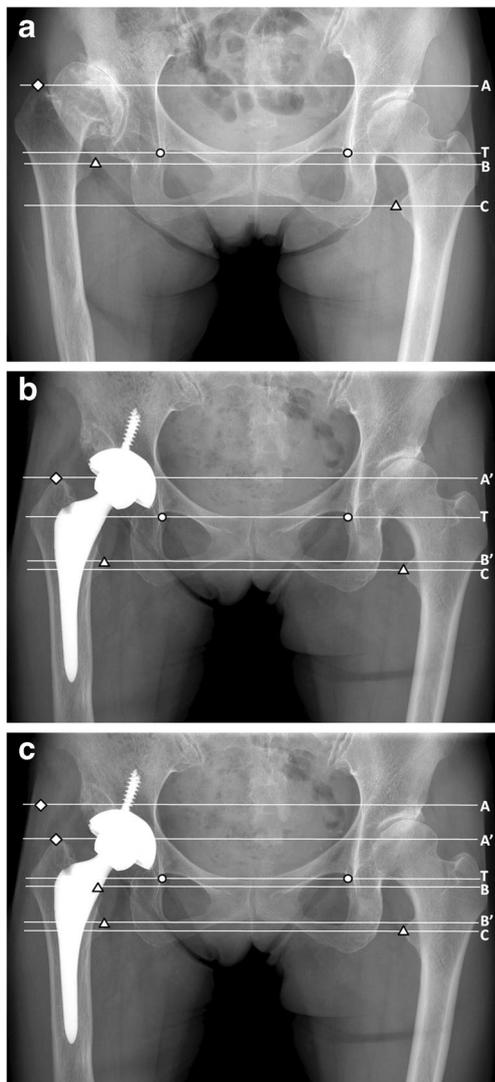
a Pre-operative anteroposterior radiographs of the pelvis in the supine position. T: trans-teardrop line; A: parallel line of the trans-teardrop line through the apex of the greater trochanter. B: parallel line of the trans-teardrop line through the rt. apex of the lesser trochanter. C: parallel line of the trans-teardrop line through the lt. apex of the lesser trochanter. \circ : apex of the teardrop; \triangle : apex of the lesser trochanter; \diamond : apex of the greater trochanter. The pre-operative leg-length discrepancy was defined as the distance between B and C. b Post-operative anteroposterior radiographs of the pelvis in the supine position. A': parallel line of the trans-teardrop line through the post-operative rt. apex of the greater trochanter. B': parallel line of the trans-teardrop line through the post-operative rt. apex of the lesser trochanter. The post-operative leg-length discrepancy was defined as the distance between B' and C. c The amount of lengthening was defined as the distance between A and A' or B and B'. The better-marked anatomical landmark (A or B) was chosen for measurement
